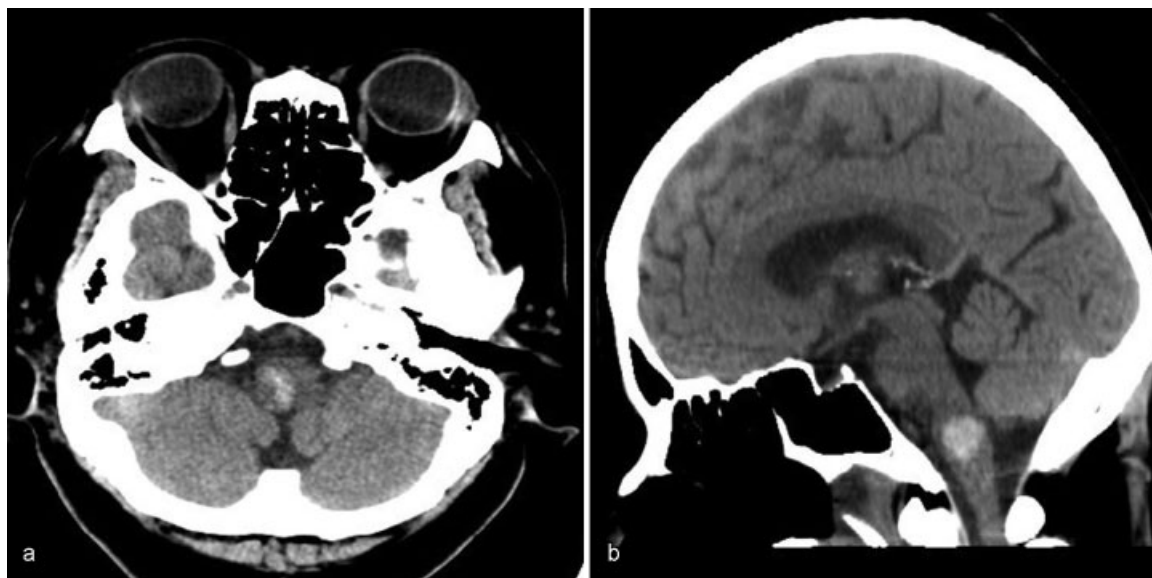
Computed tomography images showing right medullary hemorrhage. (a) Axial. (b) Sagittal.
